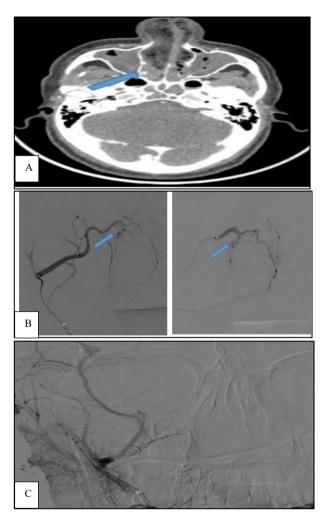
(A-C): A-Axial CT images reveal a pseudo aneurysm of the sphenopalatine artery on right side. B: External carotid angiogram reveals a vascular blush originating from the lateral nasal branch of sphenopalatine artery arising from right distal internal maxillary artery. C: External carotid angiogram AP view shows complete resolution of the vascular blush post embolization.
